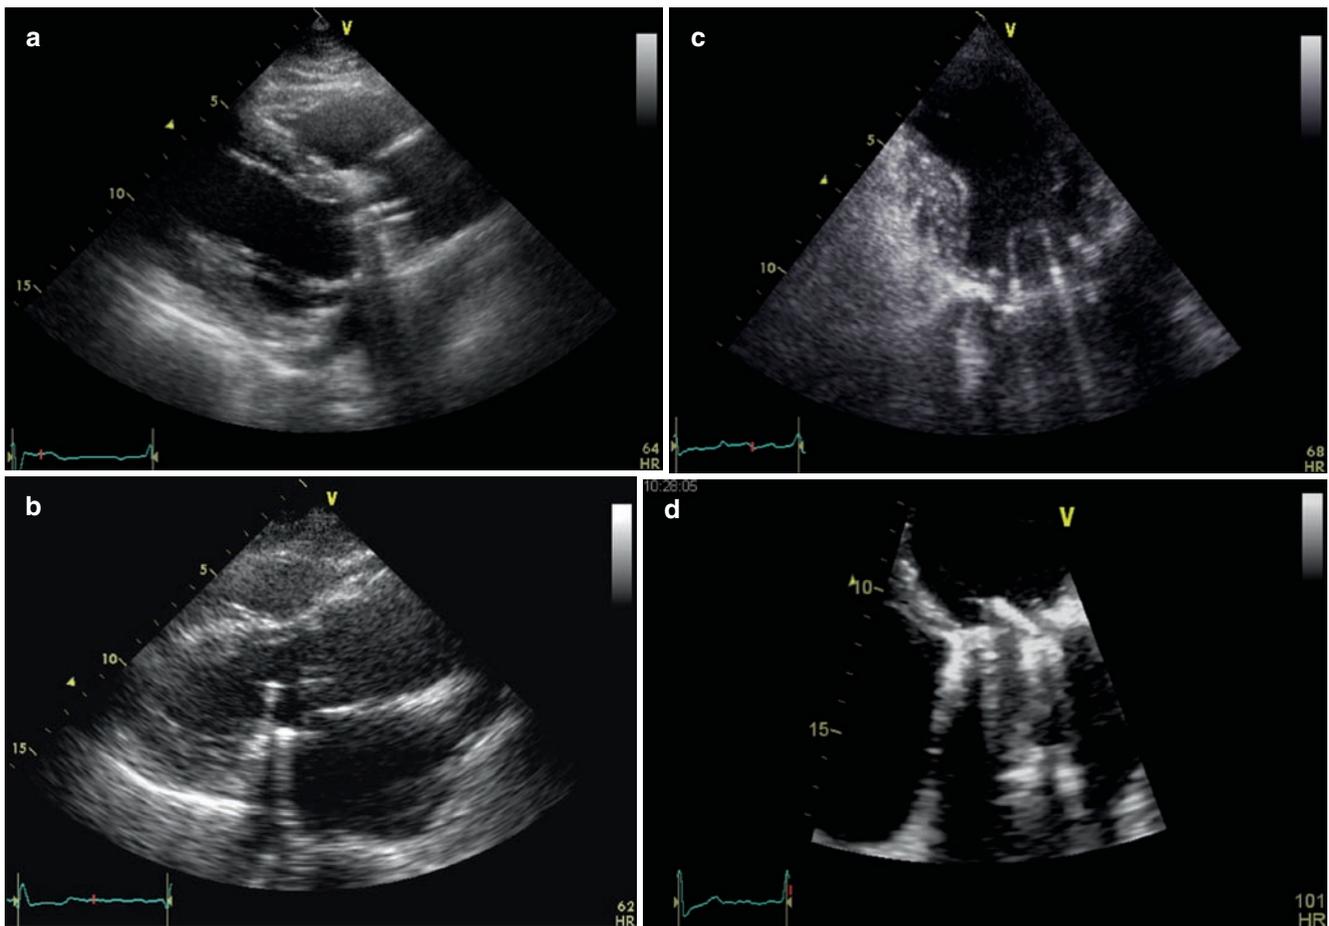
2D echocardiographic characteristic features of mechanical heart valve. (a) Bileaflet-tilting-disc valve in aortic position visualized from parasternal approach. (b) Single-tilting-disc valve in mitral position
